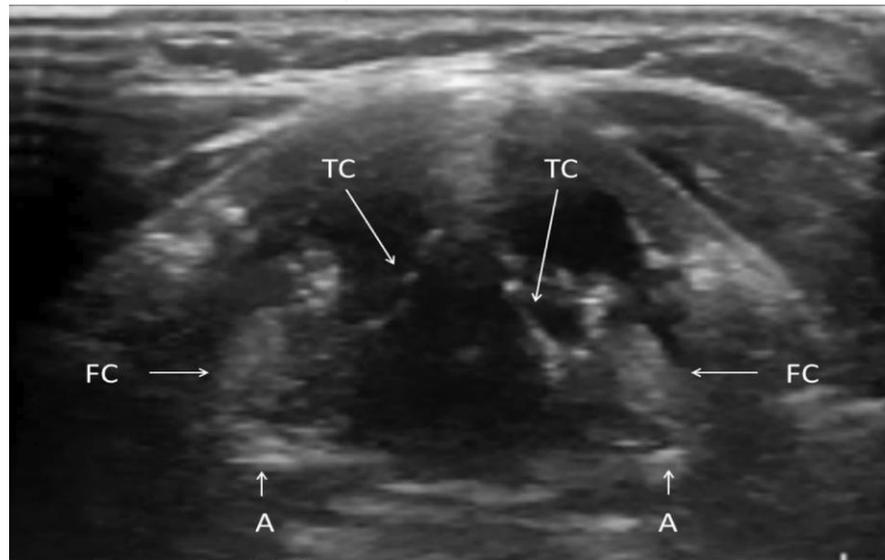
Laryngeal ultrasound.
